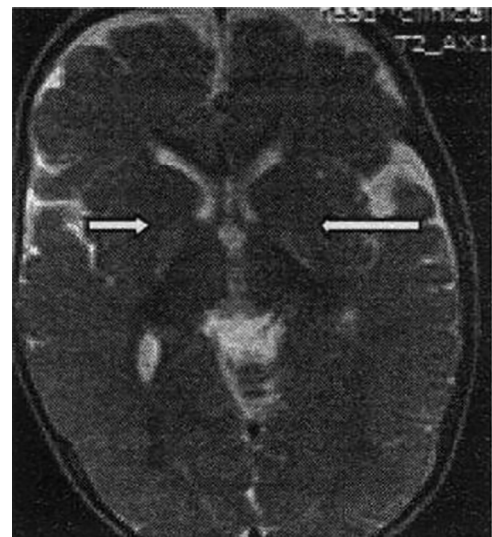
Case 2. Axial T2W magnetic resonance image showing symmetric hyperintensities in the globus Pallidus (arrows).
